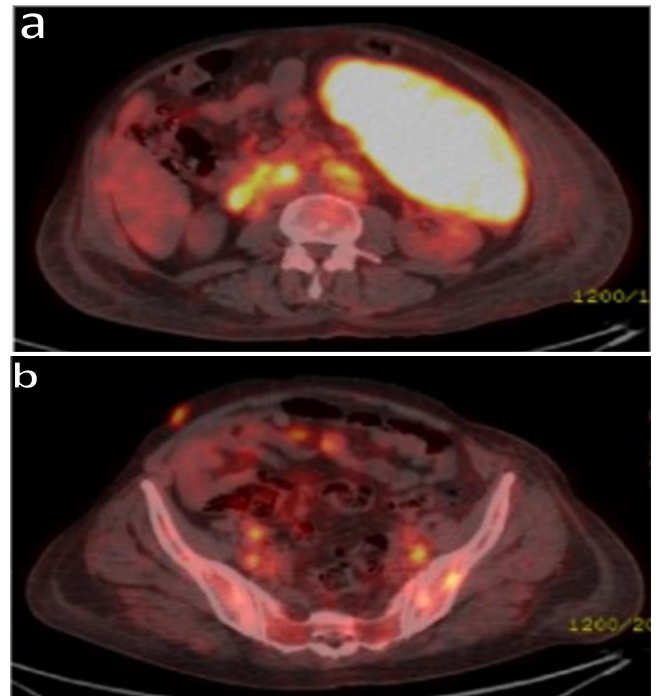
PET/CT revealed multiple low-to-moderate hypermetabolic lymph nodes with conglomeration and chain-like extension in the cervical, thoracic region, abdomen and pelvis, and a significantly increased spleen size was detected in addition to significant diffuse F-18 FDG uptake in the parenchyma of the spleen
